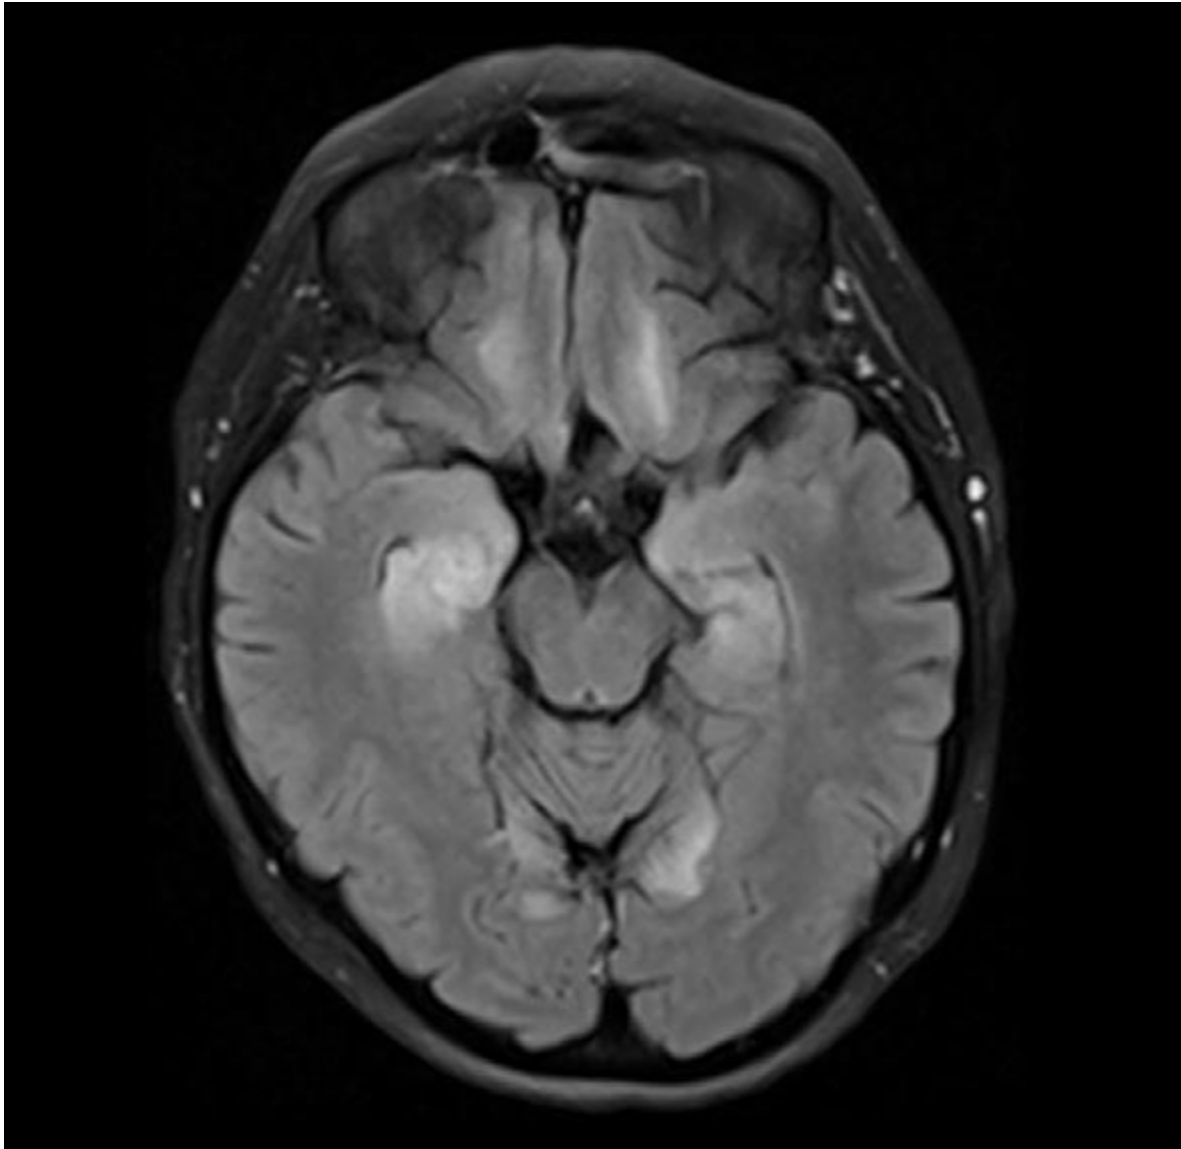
Medial temporal lobe abnormalities in GAD encephalitis. GAD antibodies were detected in a 53-year-old female patient with generalized seizures, gait ataxia, downbeat nystagmus and cognitive deficits. MRI showed FLAIR hyperintensities in the medial temporal lobes that progressed at follow-up, now extending into insular and frontal cortex. Oncological work-up revealed a gall bladder carcinoma. Immunotherapy with IV steroids, plasma exchange, rituximab and cyclophosphamide resulted in remission of seizures and cerebellar symptoms, while anterograde memory impairment persisted.
